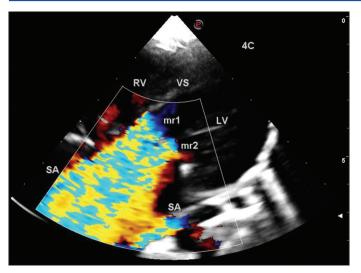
Single atrium – Apical 4 ch view – two distinct jets of mitral regurgitation visualized, which lower down in the left atrium coalesce together
